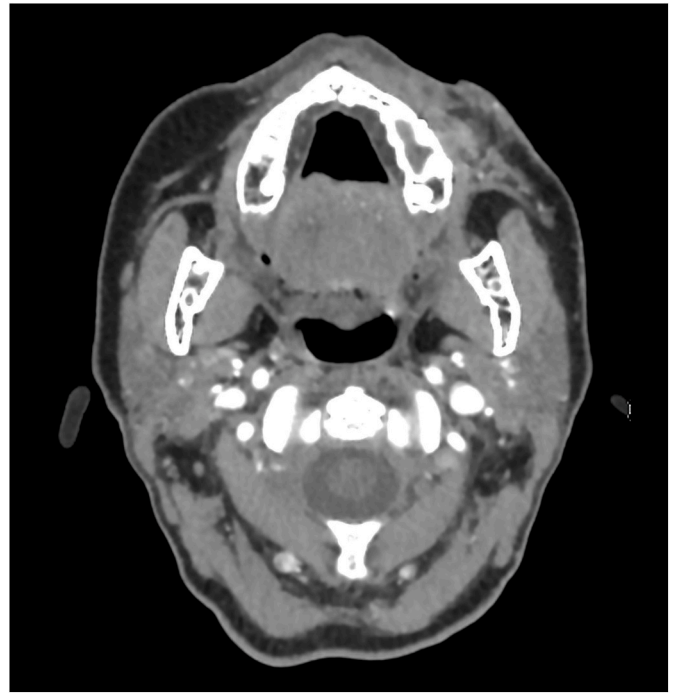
Patient 1. Post treatment Contrast Enhanced CT. No residues of diseased vessels.
